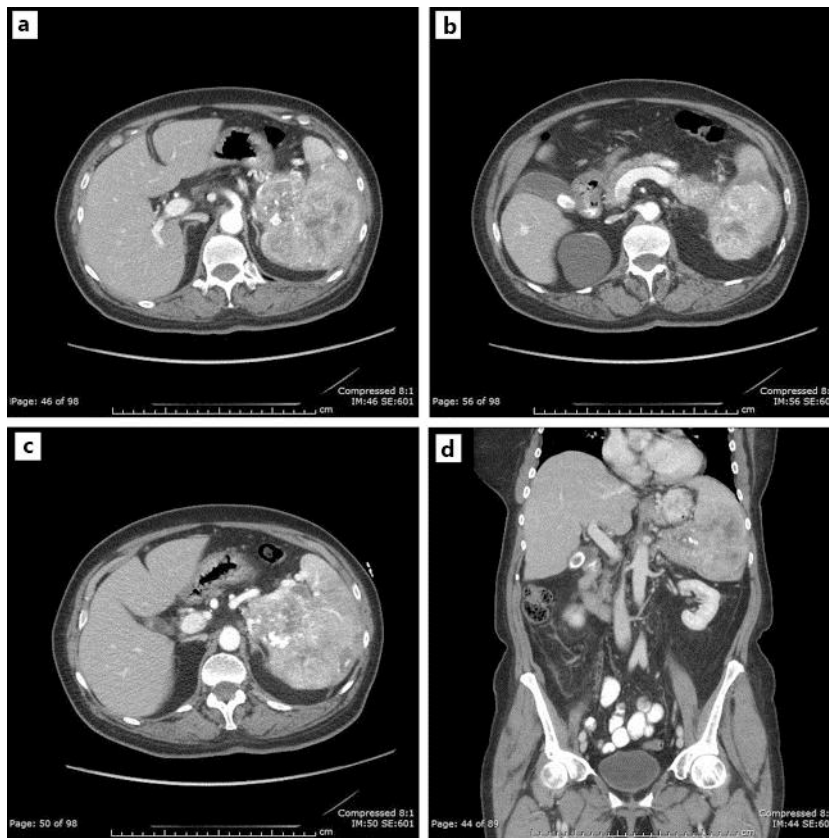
CT scan at diagnosis (April 2011). The CT scan of the abdomen revealed a large tumor in the left hypochondriac region, located cranial to the tail of the pancreas and expanding into the spleen; there was no invasion of the kidneys or adrenal glands.
